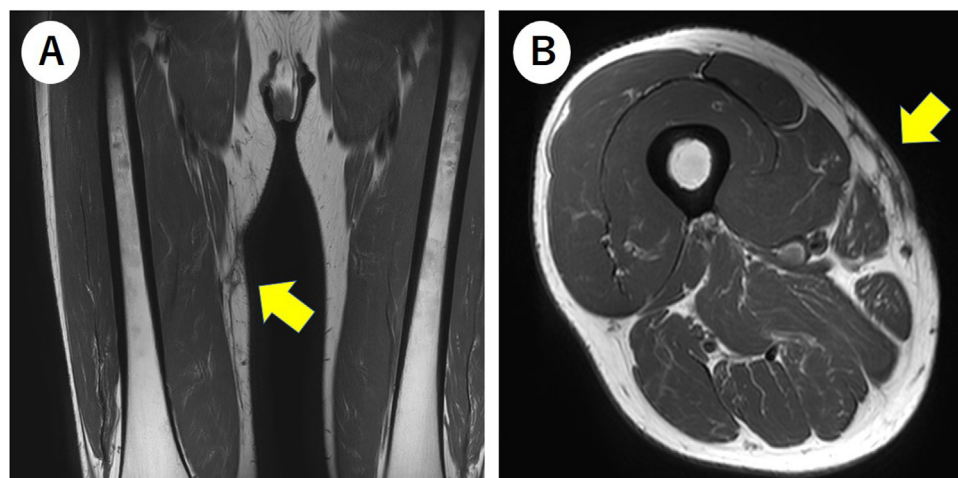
Postoperative MR images of the right thigh.
